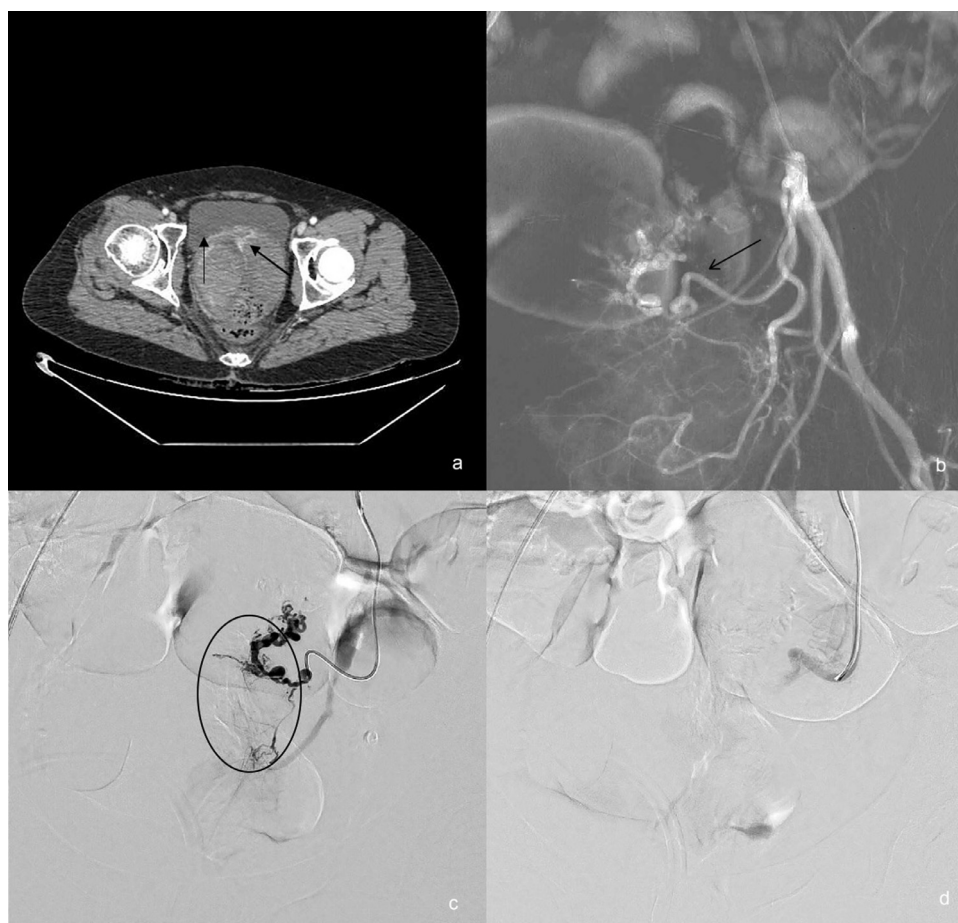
A 50-year-old woman with a history of pelvic pain, metrorrhagia, and drop in hemoglobin value. Contrast-enhanced CT scan demonstrates a heterogeneous mass that surround uterine cervix with multiple bleeding foci (a, black arrows). Selective left hypogastric arteriogram and roadmap showing homolateral uterine artery (b, black arrow). Superselective Digital Subtraction Angiography (DSA) of uterine artery performed with microcatheter: intra-arterial injection confirms the presence of multiple small bleeding foci and hypervascularization (c, black circle). Transcatheter arterial embolization with 300-500 μ m microspheres: final DSA control demonstrates no residual vascularity within the lesion on the left side (d).
